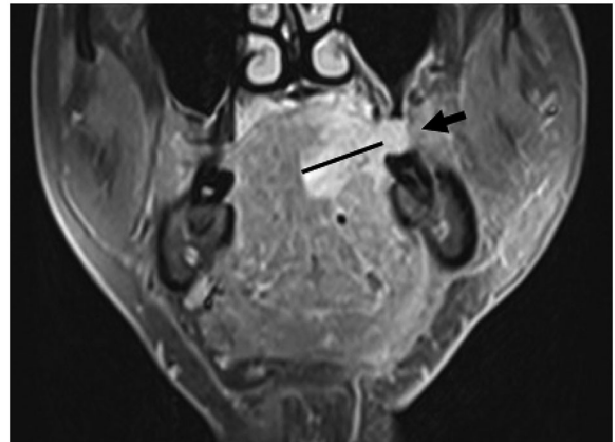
Coronal T1-weighted fat-suppressed contrast-enhanced MR image shows exophytic tumor growth (arrow). The exophytic part of the tumor was excluded when measuring the invasion depth. MR: magnetic resonance.
